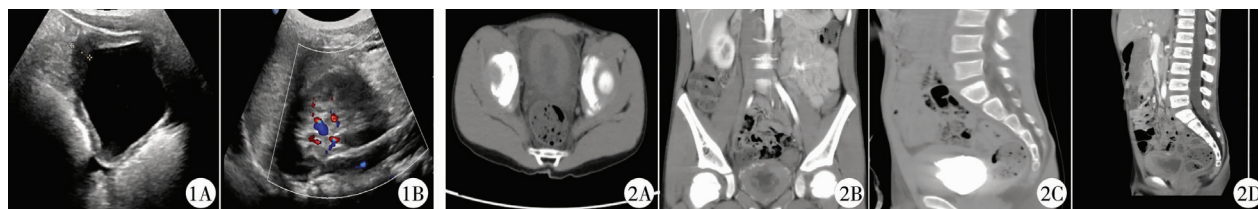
典型病例超声检查图像。A. 超声显示不规则的膀胱壁增厚达 1 cm,类似于肿瘤。B. 多普勒彩超见膀胱壁内血流丰富。图 2 典型病例 CT 图像。A. 膀胱壁弥漫性增厚,边缘毛糙。B. 膀胱腔内体积较小,增厚膀胱壁密度不均匀。C. 对比增强 CT 显示膀胱壁血供丰富,呈明显不均匀强化。D. 膀胱内壁尚光整,未见明显充盈缺损。
